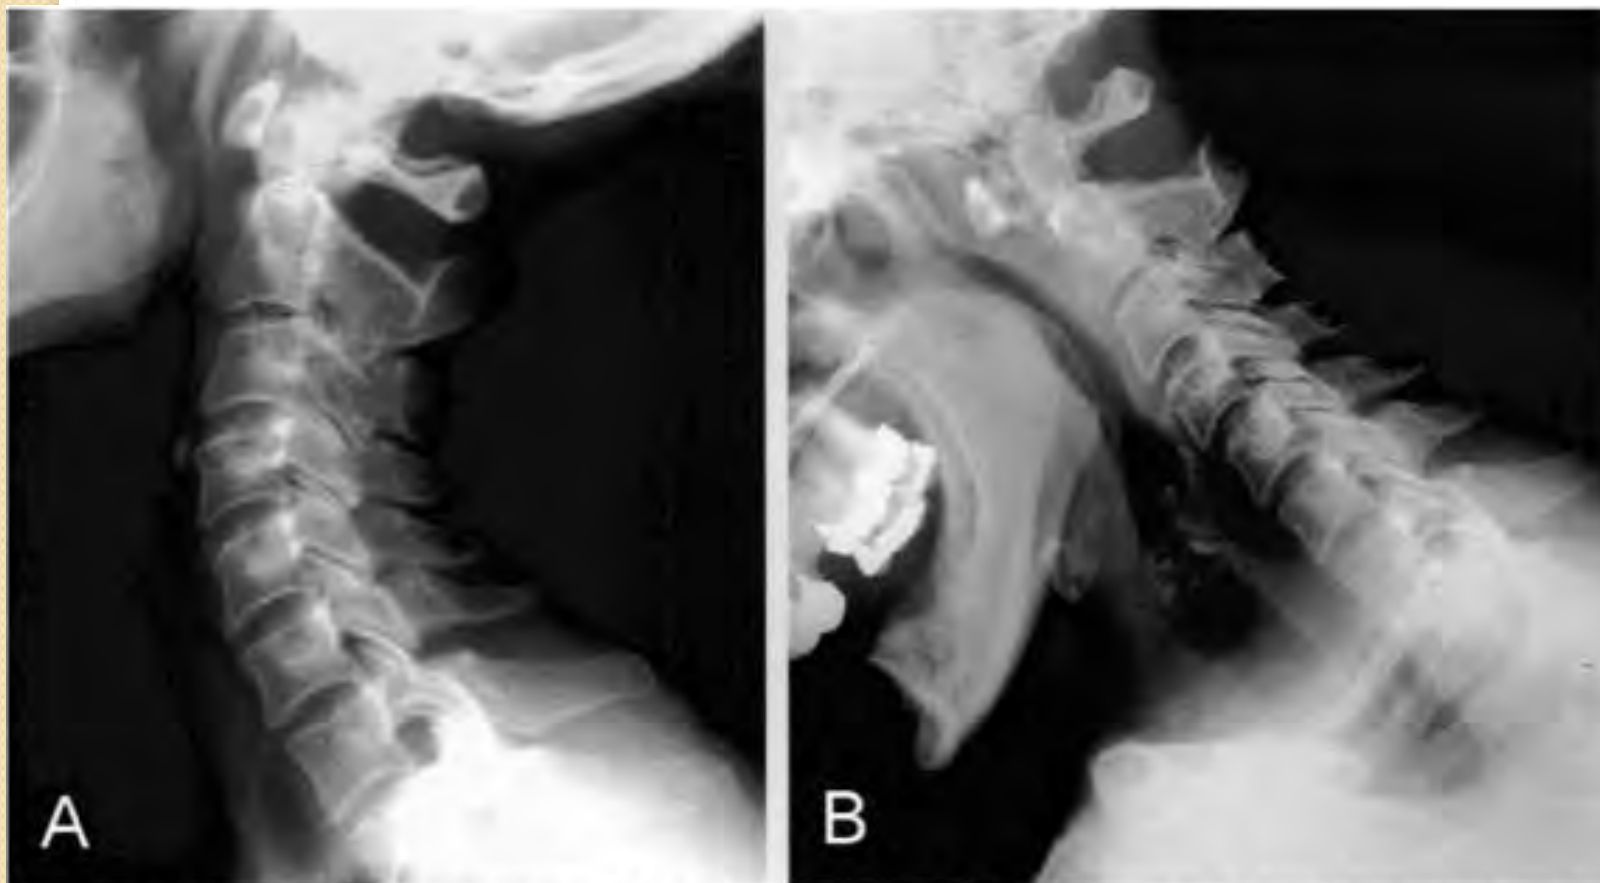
Dynamic lateral radiographs of the cervical spine (A- hiperextension; B- hiperflexion), showing atlantoaxial instability
